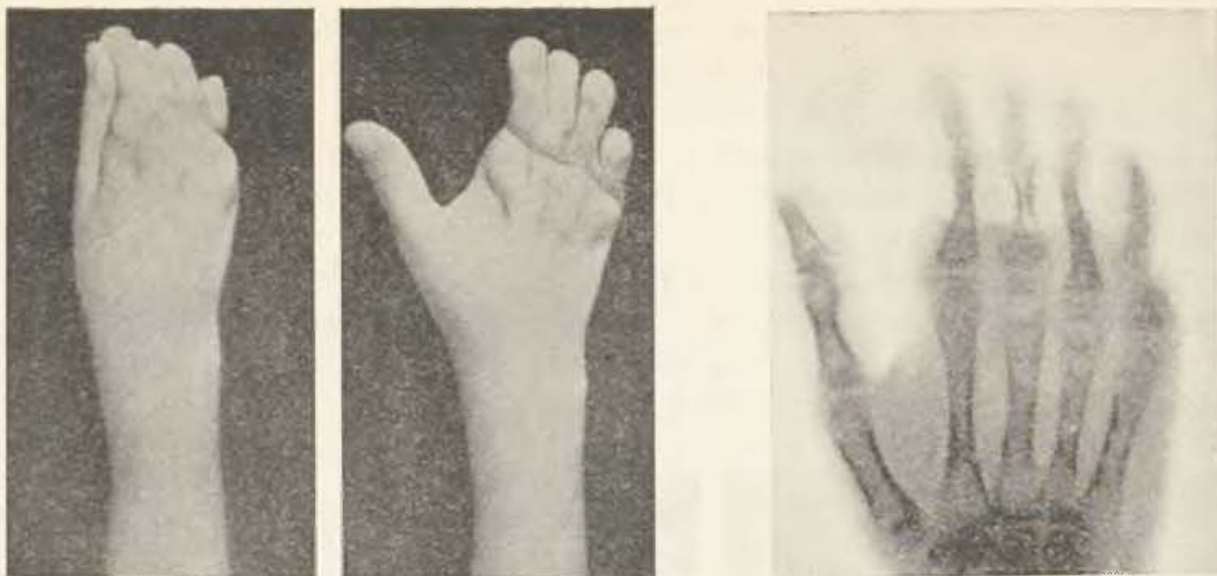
View of palm and dorsum of right hand. — Fig. 10. X-ray of four fingers reconstructed by transplantation of toes. Index, middle and ring fingers show bony union, while little finger non-union
